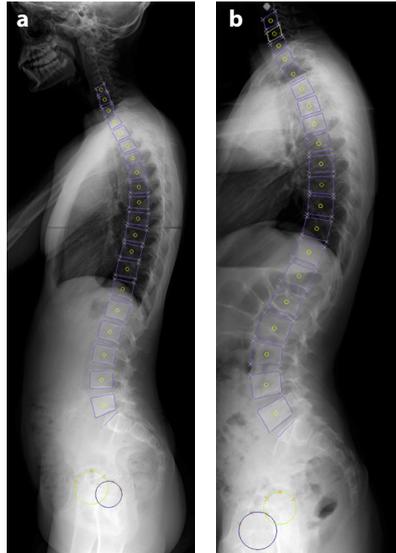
Measurements using the SpinIX software. Radiographs of a thoracic scoliosis (a) and lumbar scoliosis case (b) are shown in the graphical user interface of the in-house developed software. After indicating the four angles of each vertebra and three points on the femoral head contours the centroids of the vertebral bodies and the hip-axis were calculated automatically.
